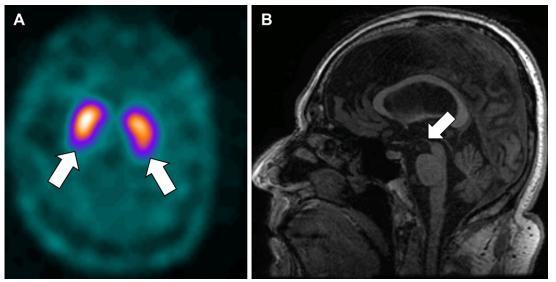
False-negative examination: complementary role of anatomic imaging. (A) Axial ¹²³I-ioflupane SPECT image shows a preserved comma-shaped appearance of the striata, compatible with a normal examination. (B) Concurrent sagittal T1-weighted MR image of the brain in the same patient shows atrophic "hummingbird morphology" in the midbrain, suggesting a diagnosis of PSP as the cause of tremors and instability. Dopamine transporter imaging sensitivity and specificity are reportedly high around 90%, but there are reported cases of false-negative imaging examinations.
